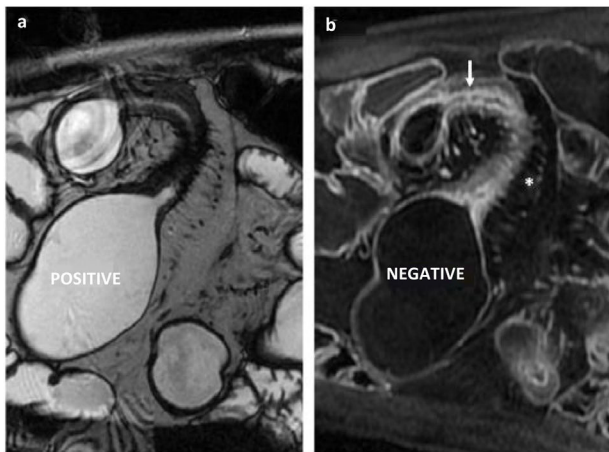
Biphasic contrast (PEG)-enhanced MRE images in a subject with Crohn's disease with inflammatory stricture of an ileum segment. Note also the dilation of the segment proximal to the stenosis. a) T2-weighted SSFP sequence. The bowel lumen is hyperintense (positive contrast). b) T1-weighted sequence with IVC. The bowel lumen is hypointense (negative contrast), which facilitates the assessment of mural enhancement (*arrow*) and mesenteric hypervascularisation known as the "comb sign" (*asterisk*).
